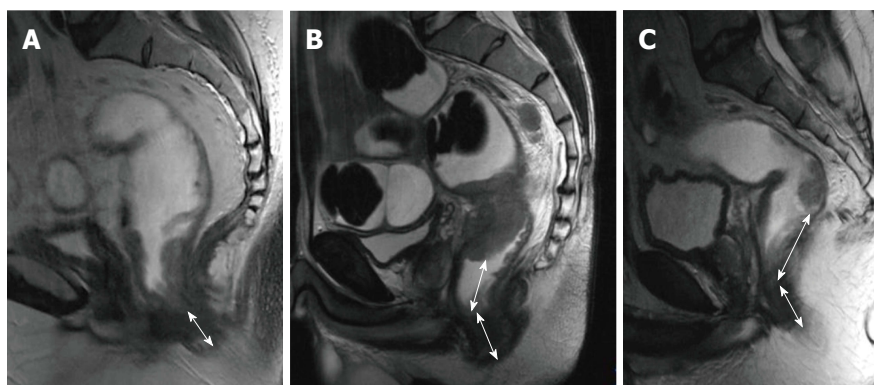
Rectal tumor levels. T2-weighted sagittal images in different patients with rectal carcinoma show distance from the anal verge (double-headed arrows) in (A) low rectal, (B) midrectal, and (C) upper rectal tumors (low rectal tumor, < 5 cm; midrectal, 5-10 cm; upper rectal, > 10 cm).
